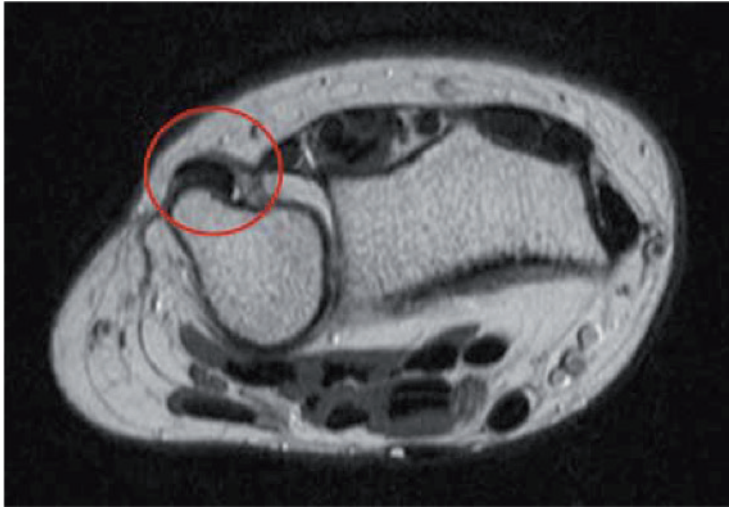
Subluxation of the distal extensor carpi ulnaris tendon. Axial T1-weighted image with the forearm neutral showing the distal extensor carpi ulnaris tendon subluxated. Circle indicates the ECU tendon.
